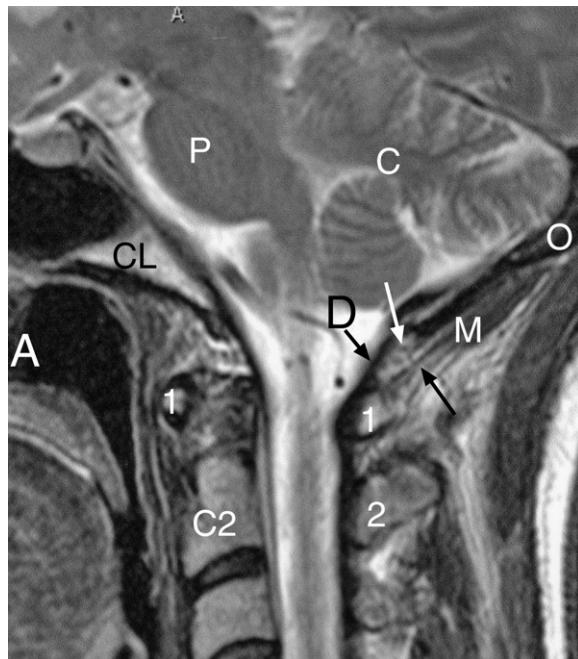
Figure ix Cervical spine MRI parasagittal T2-weighted image of a 54-year-old female patient. Note the connective tissue bridge (between the black and white arrows) connecting the rectus capitis posterior minor muscle (M) and the posterior cervical dura (D).
